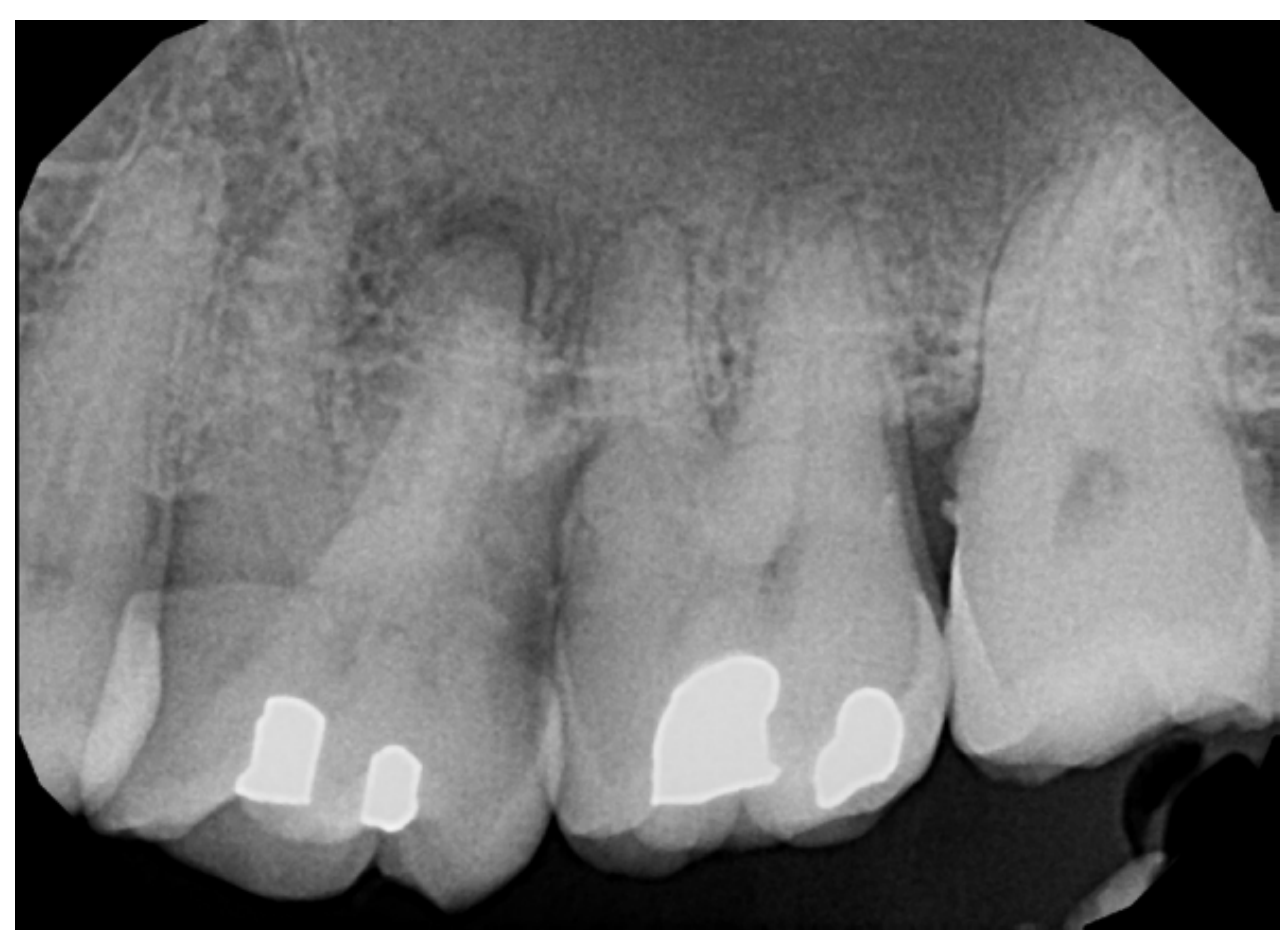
Periapical xray reveals loss of PDL at apex of palatal root of #14 and generalized moderate horizontal bone loss in the upper left quadrant.
